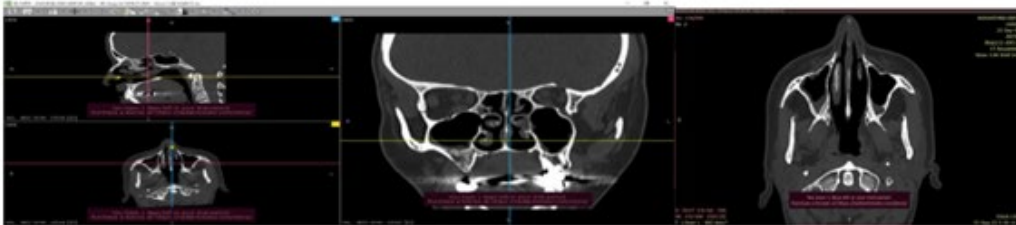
CT shows uneven parietal thickening of the mucosa membranes sinus
